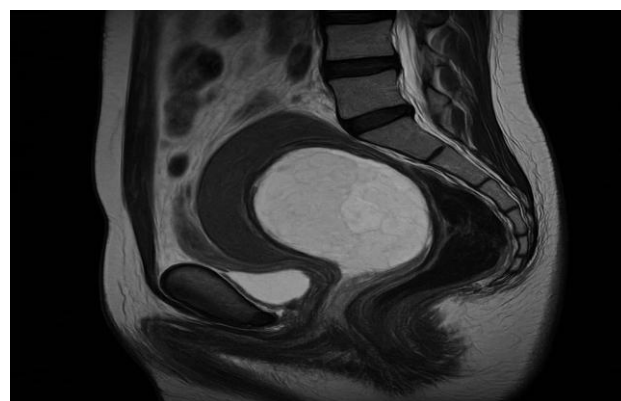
MRI picture revealing sharply defined lesion with high T1 and T2 signal intensity, with suppression on fat saturation sequences-suggestive of a fat-containing tumor, most likely lipoleiomyoma.
